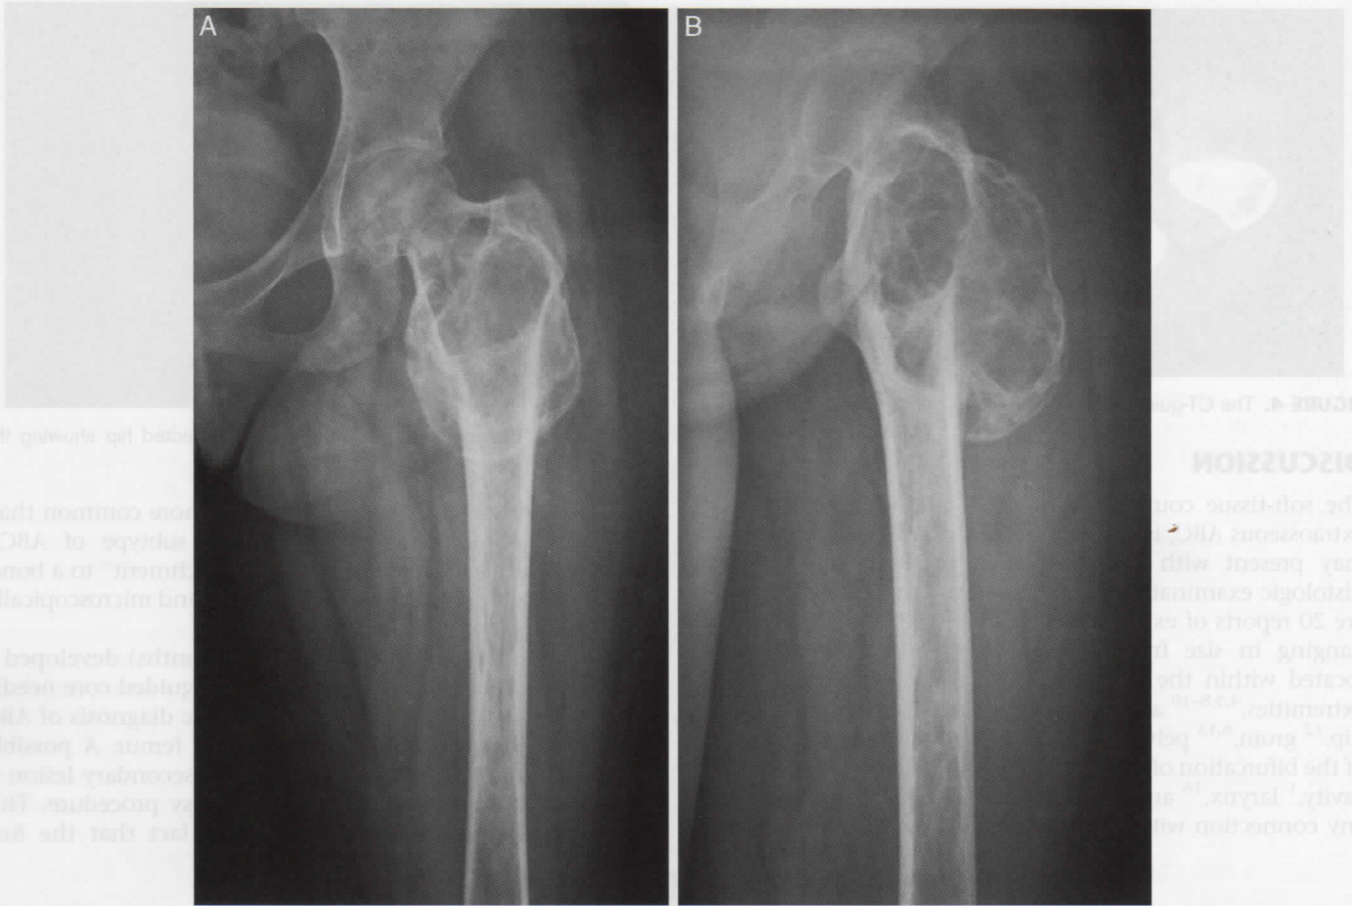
Anteroposterior (A) and lateral (B) radiographs of the affected hip 5 months after the initial evaluation of the patient showing the mineralized secondary aneurysmal bone cyst.
